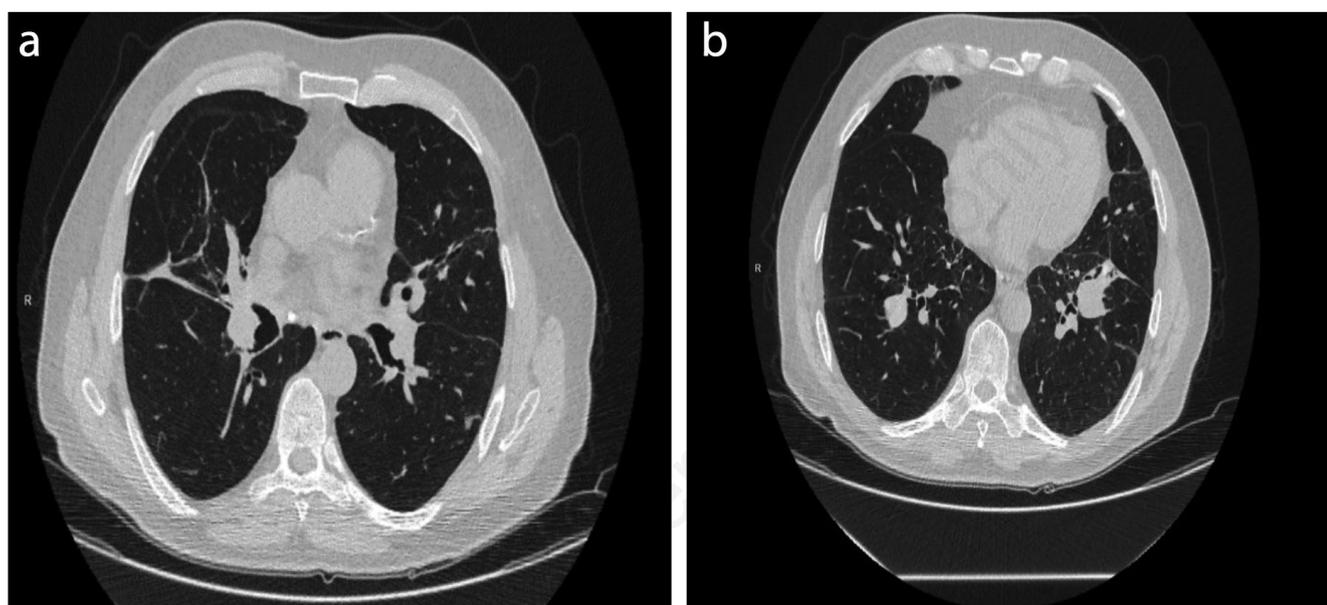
Thorax CT revealing narrowing of the upper division bronchus (a) and two nodules in the lateral segments of both lower lobes (b).
